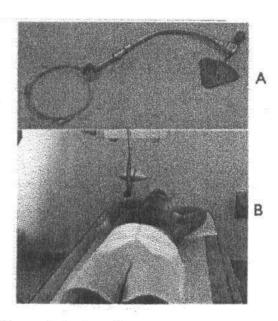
(A) Shadow shield components. (B) A shadow shield suspended above the radiographic beam-defining system casts a shadow over the protected body area. ⁽¹⁾
